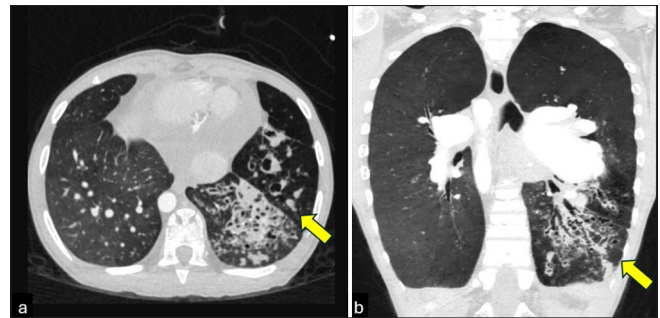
Computed tomography images in (a and b) axial and coronal plane in lung window showing clusters of cystic bronchiectasis in the lingula and left lower lobe with air-fluid levels (yellow arrows).
